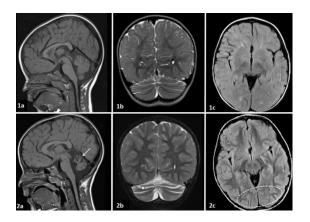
Brain MRI of Case 1: <u>Panel 1</u> - Brain MRI at the age of 4 months: Sagittal TSE-T1w (1a) and coronal TSE-T2w (1b) showed no significant morphological abnormality, with asymptomatic small pineal cyst; axial T2w-FLAIR (1c) revealed a mild delay in deep white matter myelination. <u>Panel 2</u> - Follow-up MRI at the age of 4 years: Sagittal TSE-T1w and coronal TSE-T2w showed marked cerebellar and vermis atrophy (2a, arrow) with folia prominence of the superior aspect of cerebellar hemispheres (2b, star). Residual altered signal intensity on T2w was still visible within deep white matter of occipital lobes (2c, dotted).
